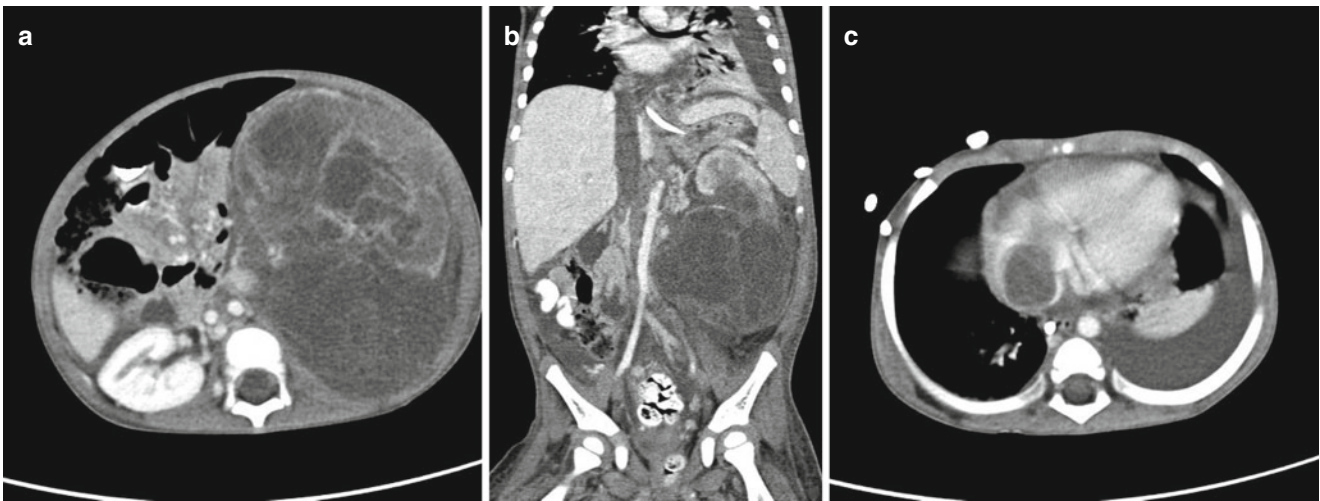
Wilms tumour on contrast enhanced CT. (a) Large left sided Wilms tumor, (b) coronal reformat showing tumour thrombus distending the IVC and extending to the chest, (c) and tumour thrombus extending into the right atrium (a left sided pleural effusion is also present)
